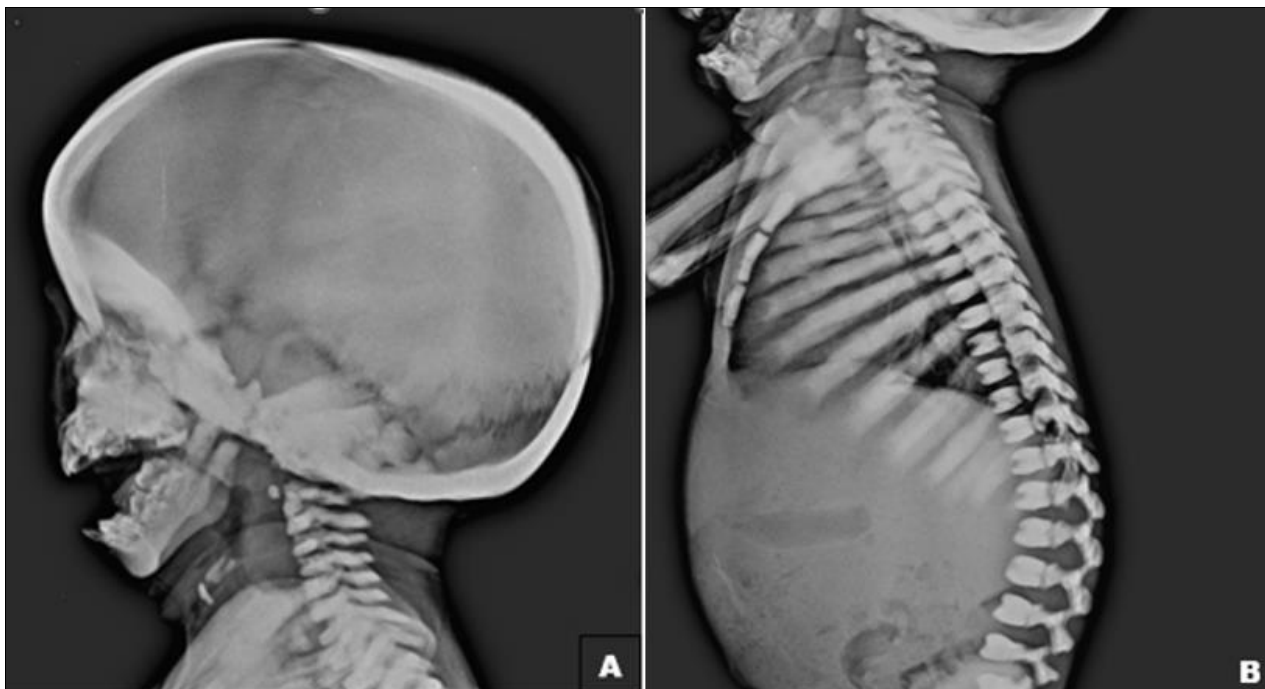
Lateral radiographs of the skull (A) and the spine (B) shows a general increase in bone density, primarily involving The medullary region. Observe the traditional end obone, or "bone-within-bone appearance," in the spine, known as "sandwich Vertebra," which is defined by dense endplate sclerosis and sharp edges.
